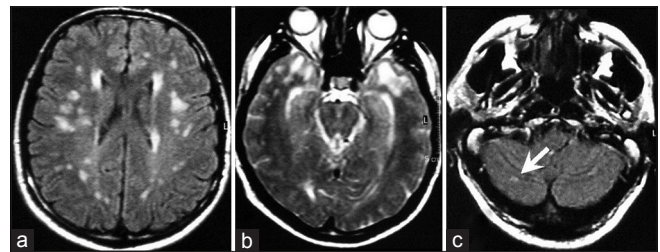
Magnetic resonance imaging of the patient. (a) Fluid-attenuated inversion recovery (FLAIR) image showing multiple confluent white matter lesions. (b) T2-weighted image showing the characteristic lesions in the anterior temporal lobe. (c) FLAIR image showing a small, ill-defined lesion in the right cerebellar hemisphere
